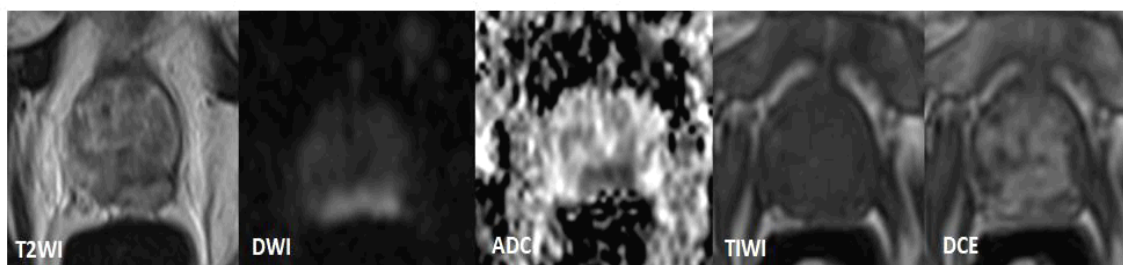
A 72-year-old man presented with a 2.9 cm focal lesion in the left posteromedial/posterolateral mid-peripheral zone of prostate with marked DWI hyperintensity, marked ADC hypointensity, intermediate T2 signal intensity, and positive DCE and focal prostatic capsule bulge (PI-RADS-5).
